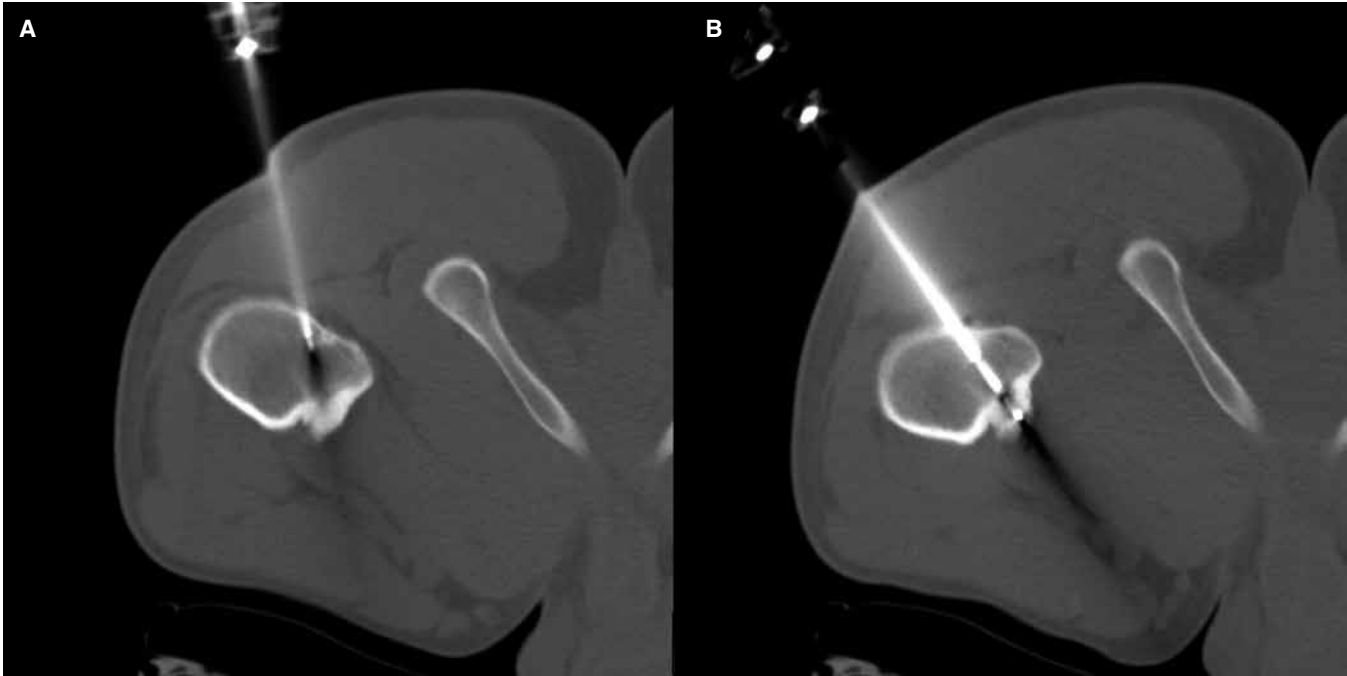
(A–B) Right hip CT scan in prone position with needle and radiofrequency ablation system at level of the osteoid osteoma.
